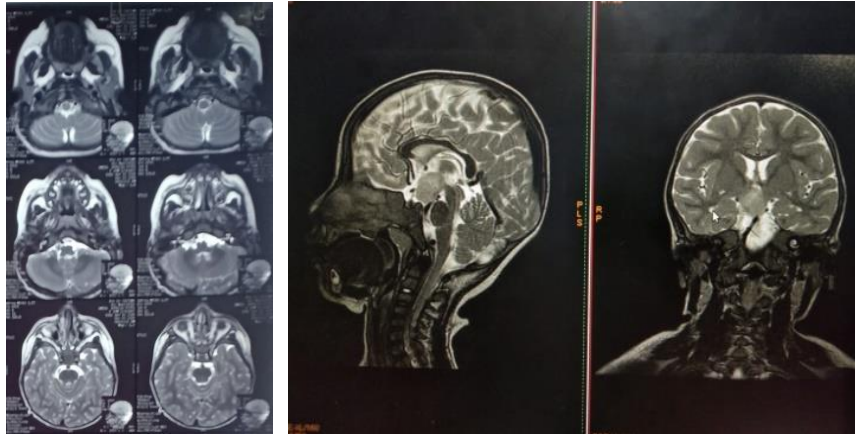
Patient’s head MRI
